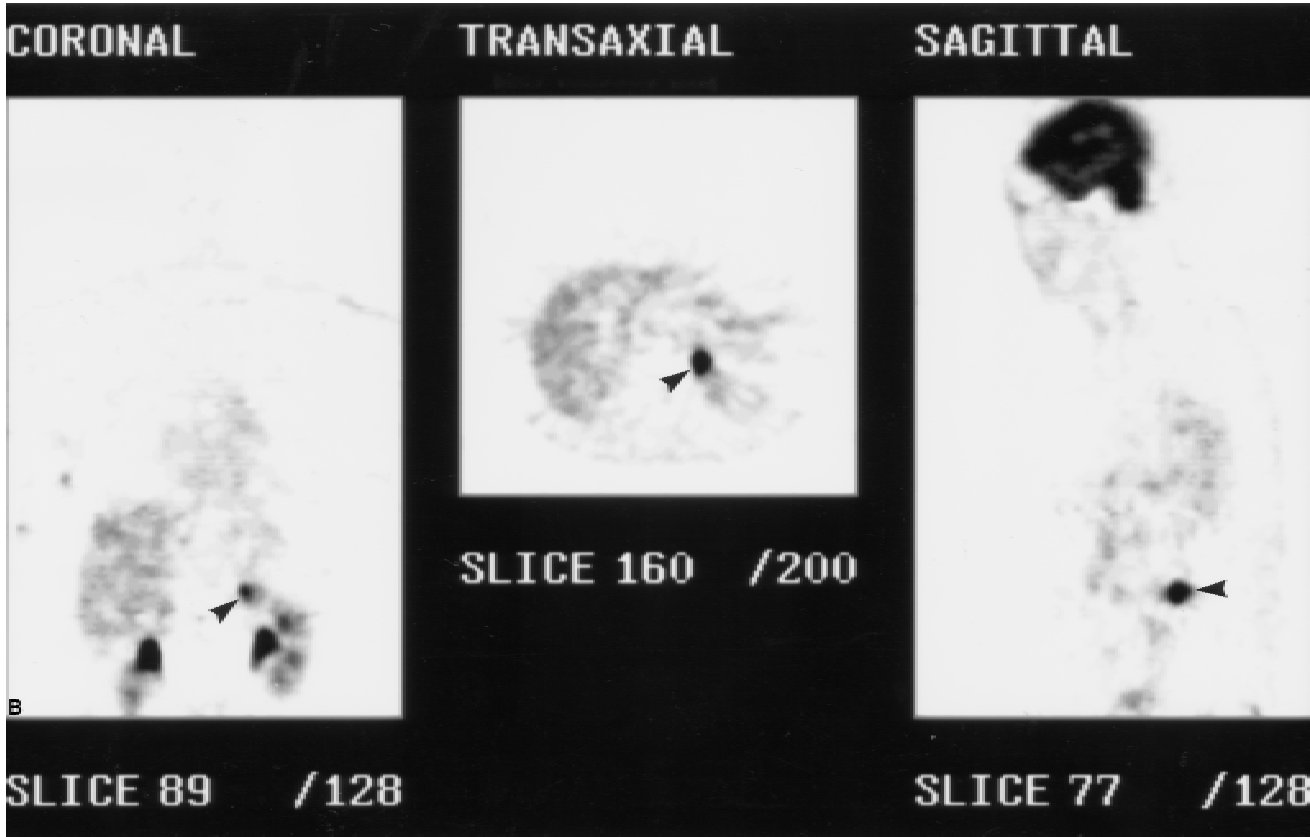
a: Patient No. 6. Parasagittal fluorodeoxyglucose positron emission tomography image demonstrates two nonpalpable axillary nodules in previously biopsied basin. Scan was performed 3 weeks after excisional biopsy of clinically solitary cutaneous recurrence in axillary dissection scar. Repeat axillary dissection revealed two of three nodes (6-mm and 10-mm) contained melanoma. b: Patient No. 6. Increased fluorodeoxyglucose uptake in left adrenal metastasis; initially missed by CT scan, but subsequently confirmed by CT-guided fine-needle biopsy.
